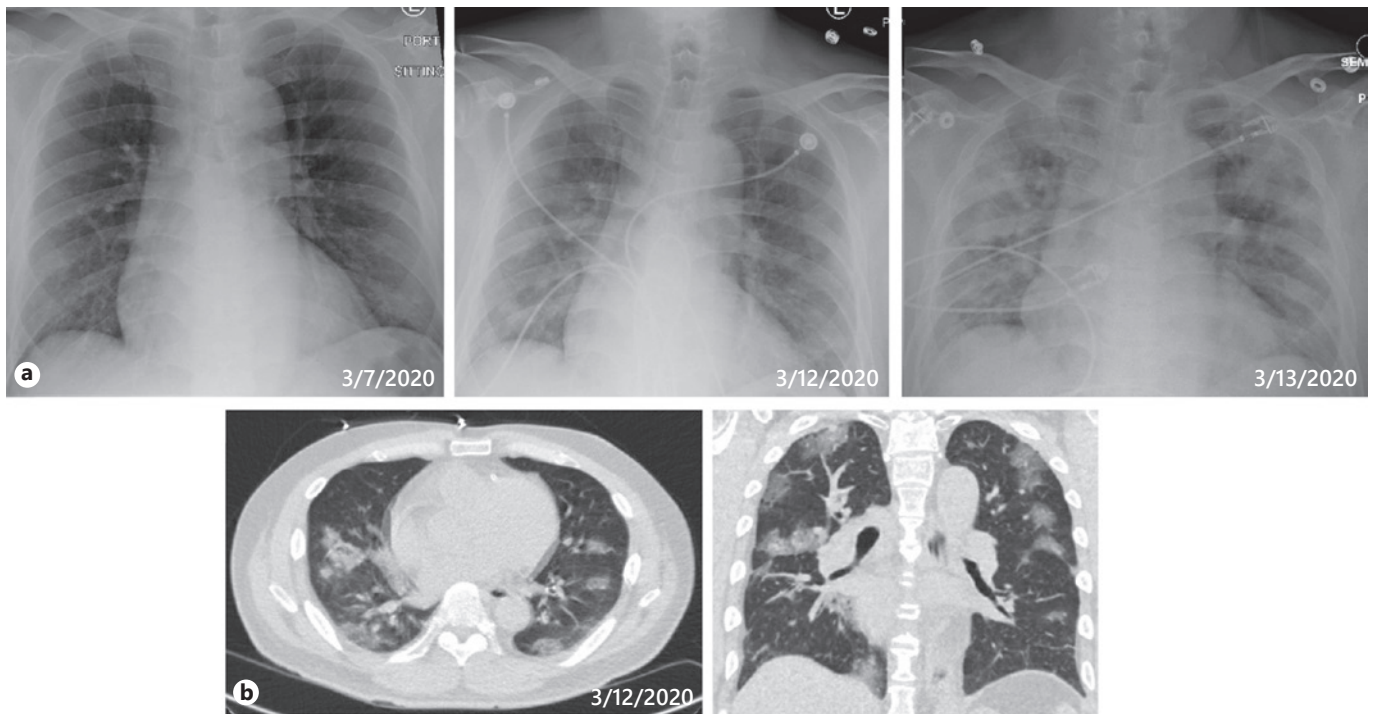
Imaging demonstrating progression of interstitial pneumonitis due to COVID-19 resulting in ARDS. a Chest X-ray sequence with interval increasing patchy opacities in both lungs consistent with evolving infectious process. b Chest CT showing new multifocal bilateral patchy groundglass opacities with a predominantly peripheral distribution. There is mild bibasal septal and centrilobular thickening. No evidence of pleural effusion or pneumothorax.
